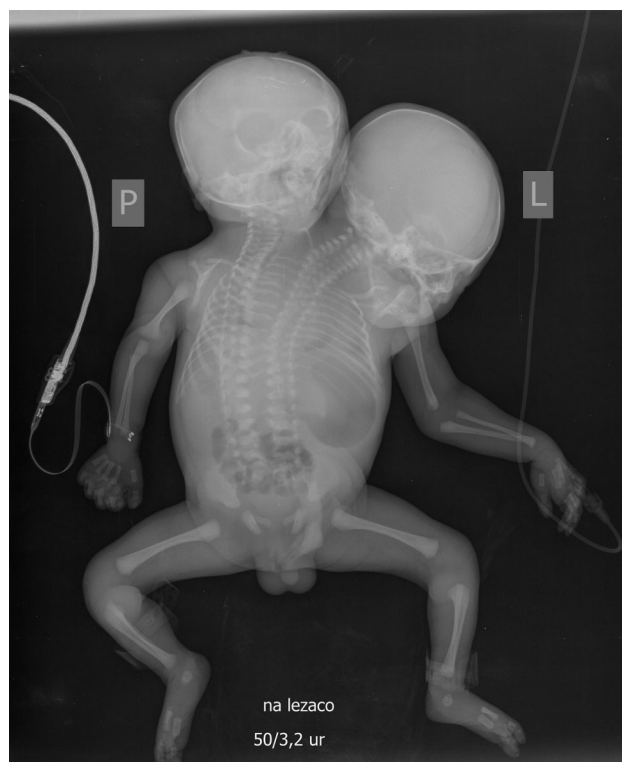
An X-ray reveals the junction of spinal columns in the sacral area.
